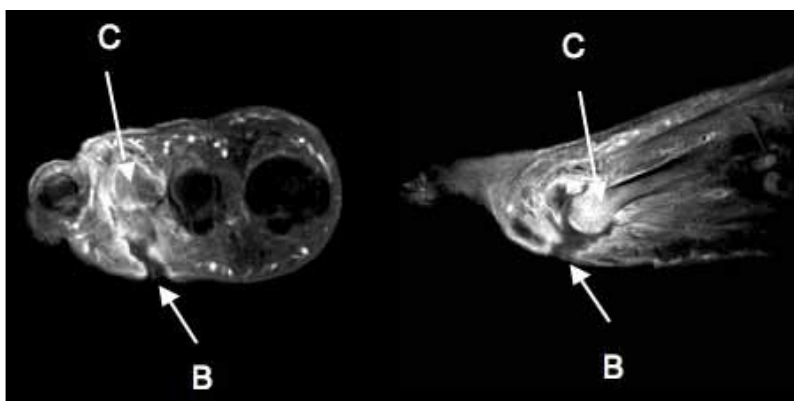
MRI scan right foot: transverse and sagittal views with gadolinium enhancement showing a sinus track (B) and an increased signal indicating osteomyelitis of the third metatarsal (C).
